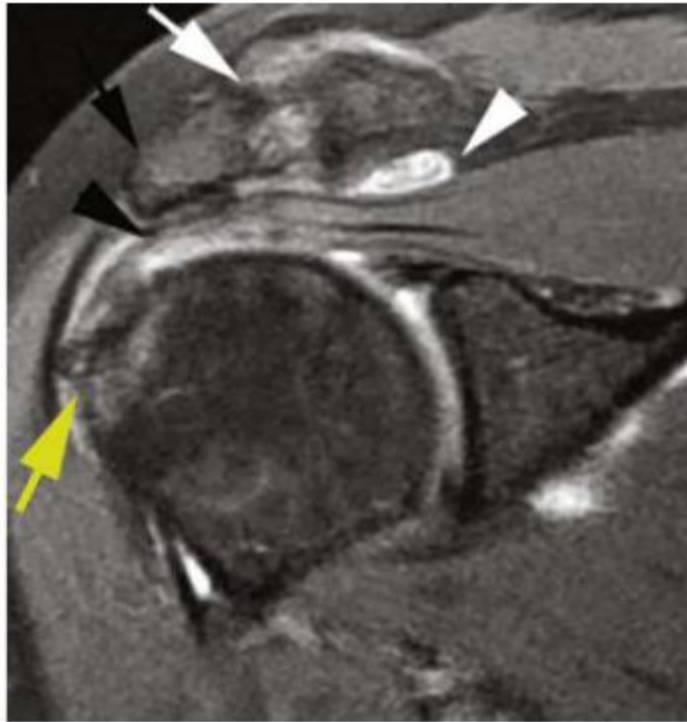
Coronal proton density-weighted fat-saturated MR image in a patient with subacromial impingement demonstrates ACJ degenerative changes (*white arrow*), low-lying acromion with a slight lateral tilt (*black arrow*), subacromial bursitis (*white arrowhead*), partial thickness supraspinatus tear (*black arrowhead*) and changes in the greater tuberosity (*yellow arrow*) (11)
